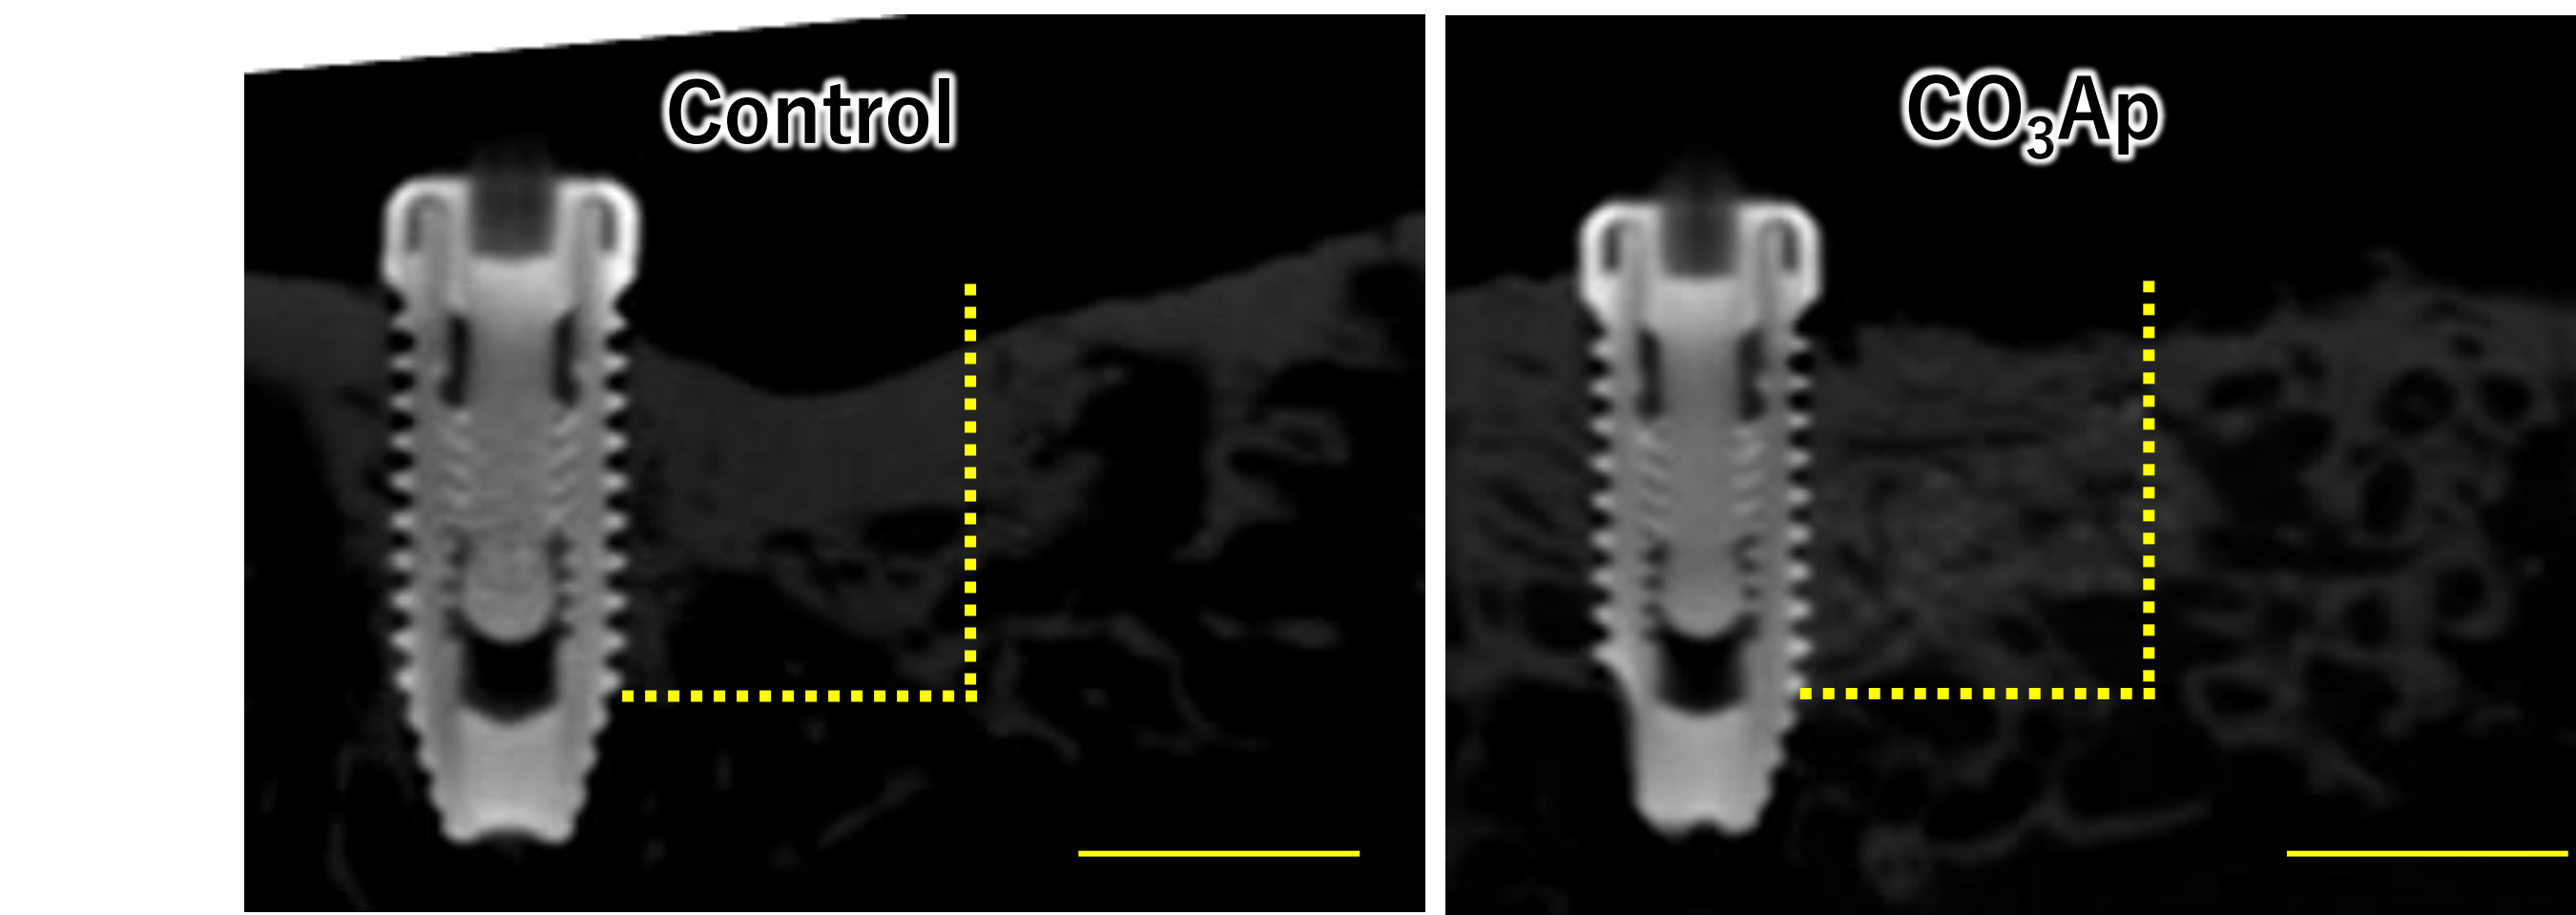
μ-CT image after a healing period of 12 weeks Bar : 5 mm
